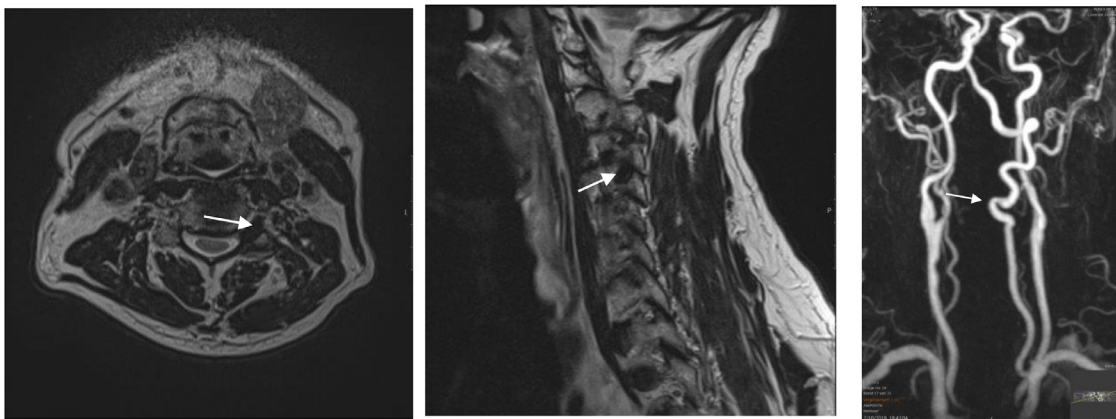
T2-weighted axial (A) and sagittal (B) magnetic resonance images show a signal-void vascular structure in the left C3-C4 intervertebral foramen. (C) Magnetic resonance angiography shows the vertebral artery loop formation (VALF).
